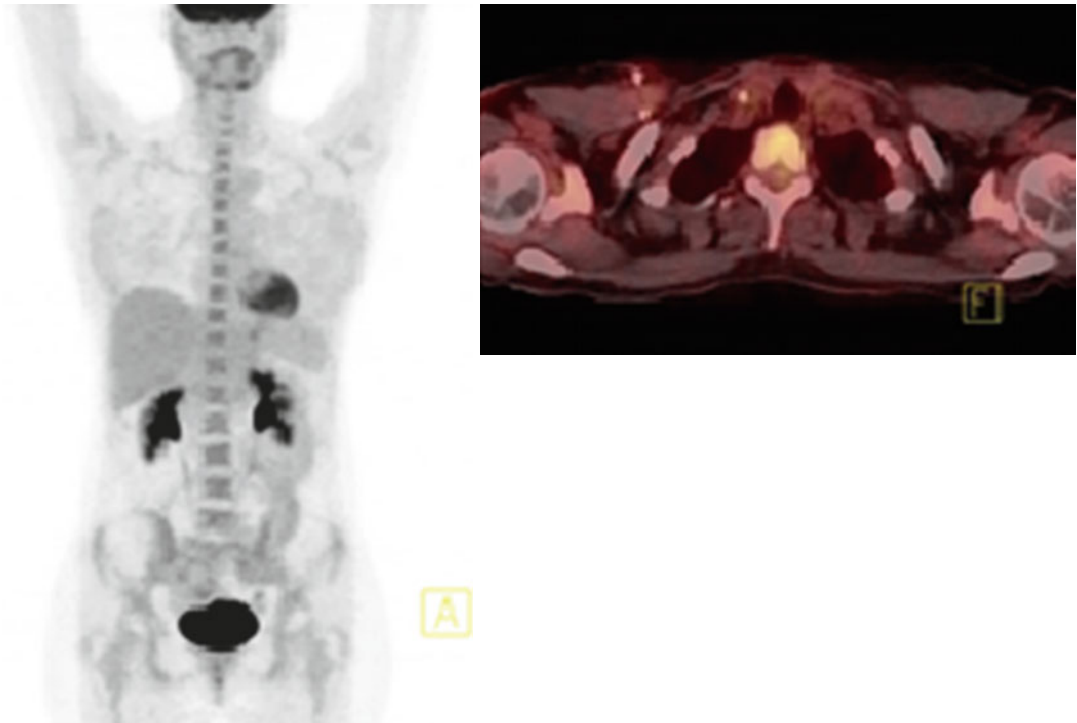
Interim PET/CT (after two cycles of ABVD chemotherapy): no hypermetabolic lesions are observed – complete remission
